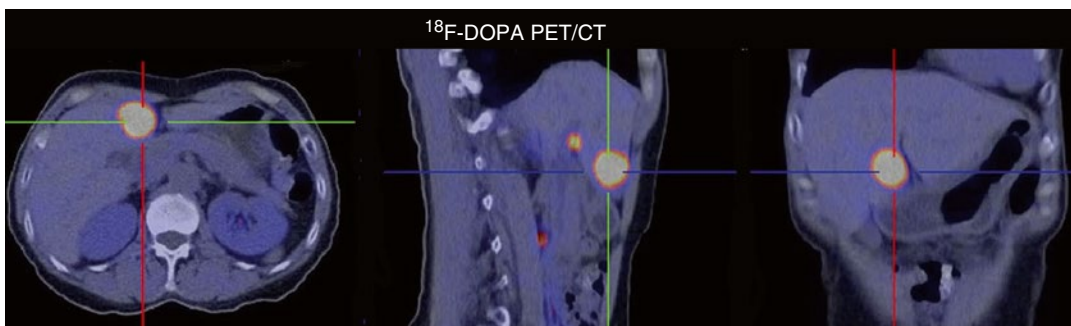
^{18}F -DOPA PET/CT shows a metastatic liver lesion in a patient with pancreatic neuroendocrine tumor
